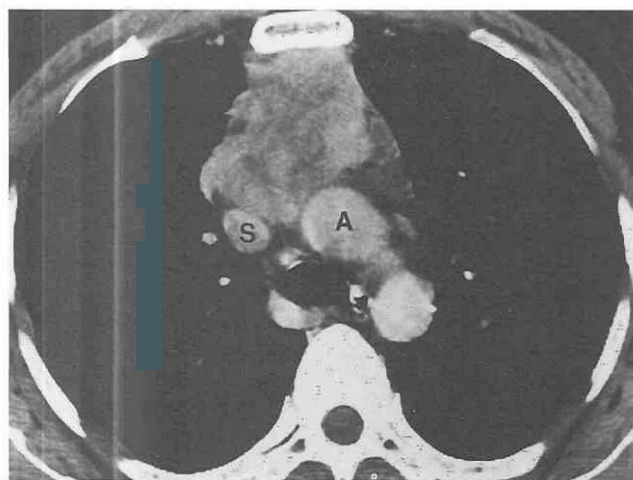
Thymic carcinoma. Contrast-enhanced CT shows heterogeneous mass in anterior mediastinum. Low-attenuation regions are consistent with necrosis. A, aorta; S, superior vena cava.
